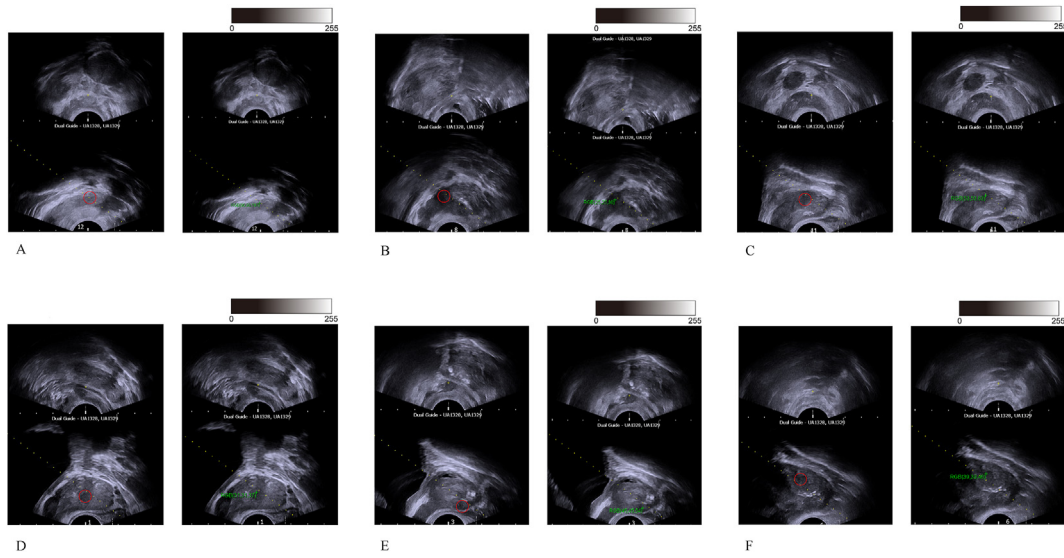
Association of transrectal ultrasound images with grayscale values and pathology reports of the prostate biopsies. A: The grayscale value of 91.23 is pathologically categorized as noncancerous. B: The grayscale value of 25.36 is pathologically categorized as noncancerous. C: The grayscale value of 53.72 is pathologically categorized as prostate cancer with a Gleason score of 6. D: The grayscale value of 31.43 is pathologically categorized as prostate cancer with a Gleason score of 6. E: The grayscale value of 45.65 is pathologically categorized as prostate cancer with a Gleason score of 7. F: The grayscale value of 39.51 is pathologically categorized as prostate cancer with a Gleason score of 8.
